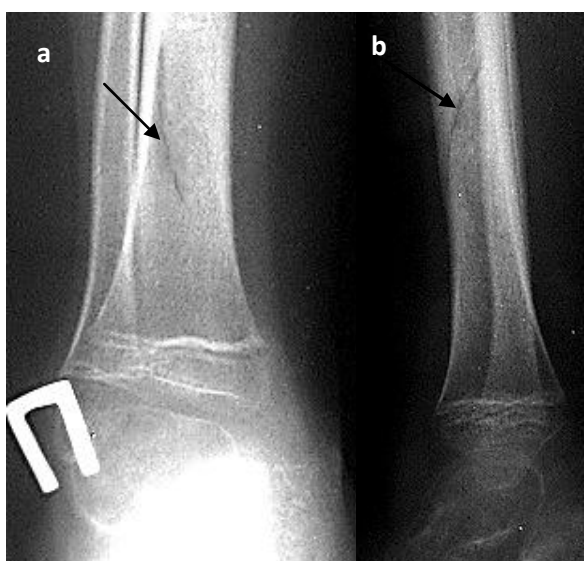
Radiograph of the right shin in direct (a) and lateral projections (b). The line of fracture lies in tibia diaphysis area, extending from a front-exterior contour of a bone to backwards-interior one, not reaching an opposite contour (arrows). Displacement of fragments is absent. Incomplete fracture of the right tibia diaphysis is detected
